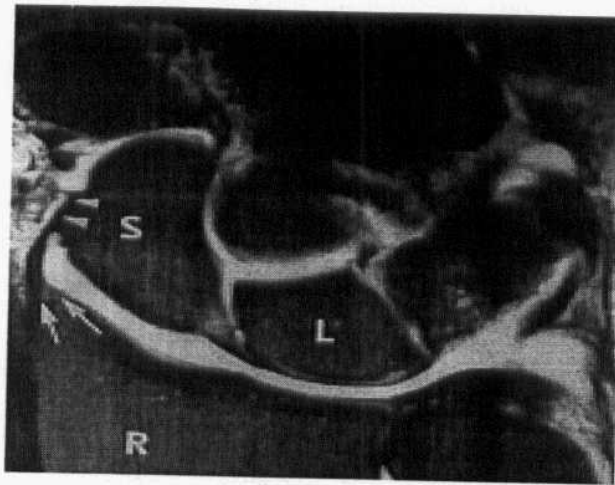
Coronal T1-weighted fat-saturated spin-echo MR arthrographic image of the wrist. The radial collateral ligament arises from the tip of the radial styloid process (arrows) and extends distally to the lateral aspect of the scaphoid (S) waist (arrowheads). L = lunate, R = radius (Quoted from Theuman , 2002).
